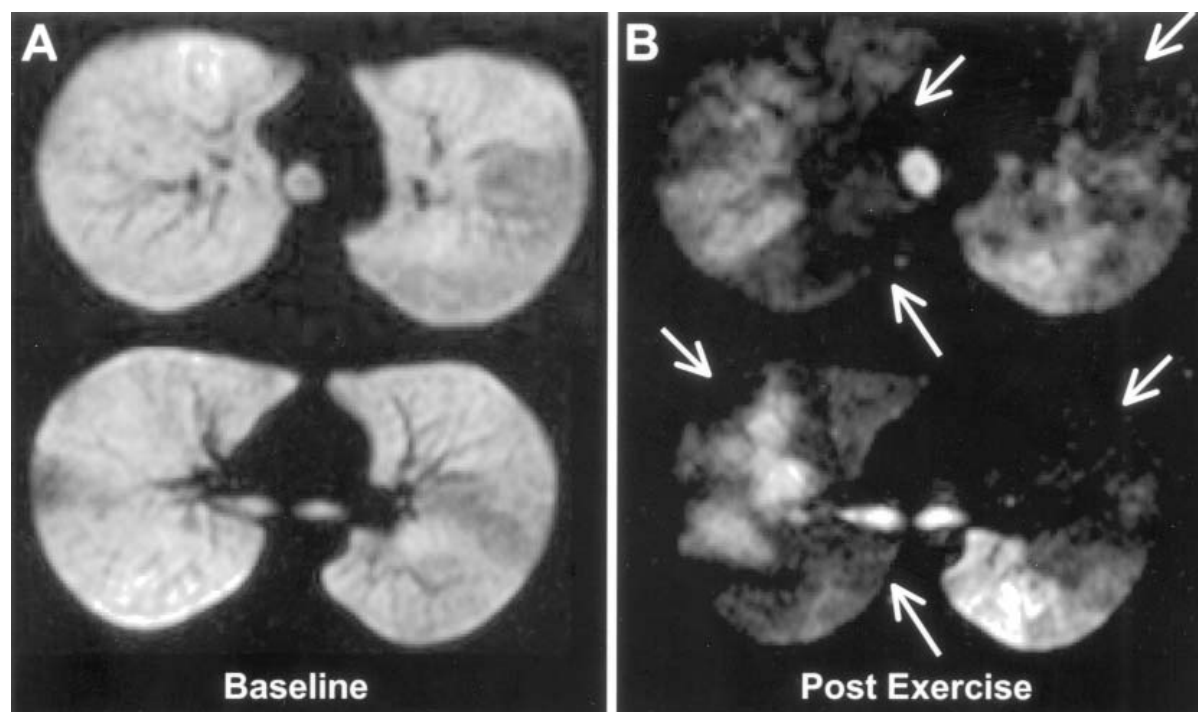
A, Axial HHe3 MR image of patient with mild asthma at baseline (FEV₁ of 103% of predicted value) shows mildly heterogeneous distribution of the gas in the lungs. B, After exercise (FEV₁ of 39% of predicted value), very extensive ventilation defects have developed. Two levels of the lung are shown for subject 395.
